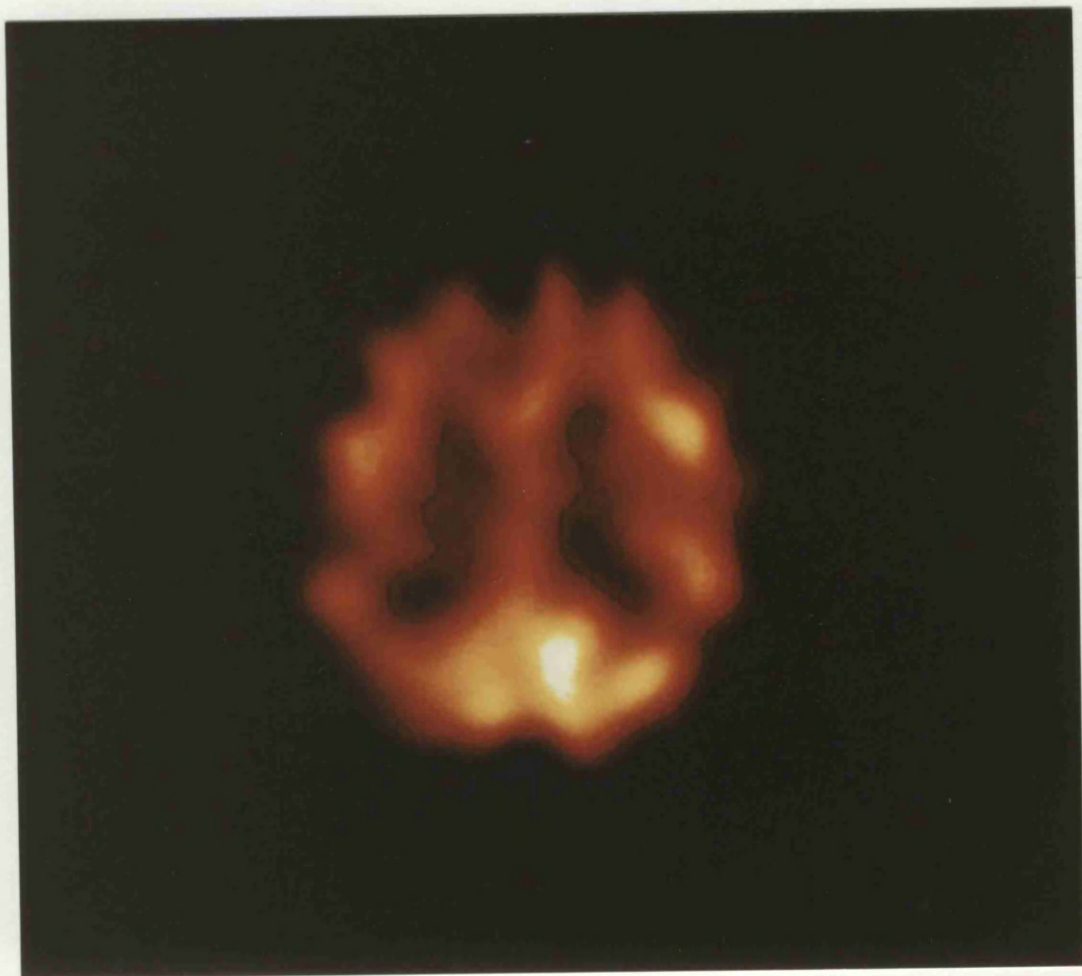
SPECT: Alzheimer's disease
